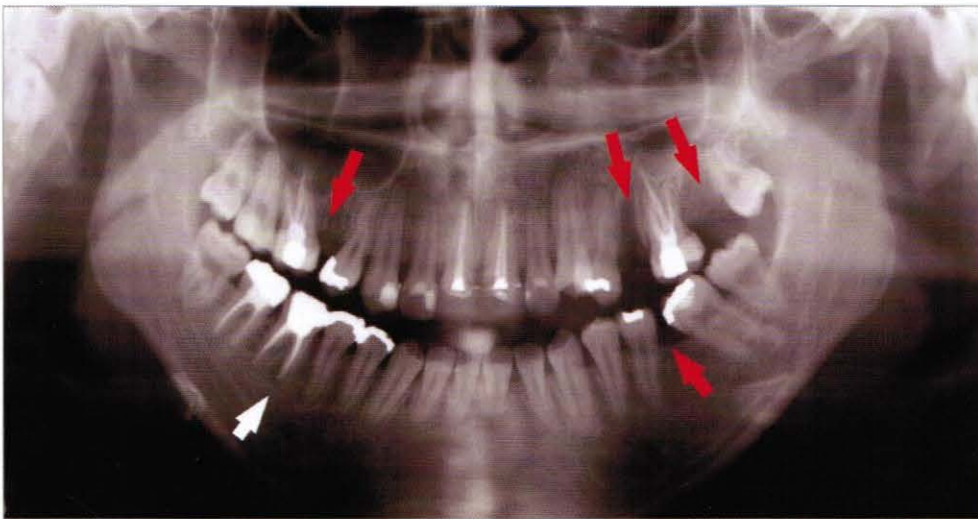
Pre-treatment panoramic radiograph (2005, 2,28)
